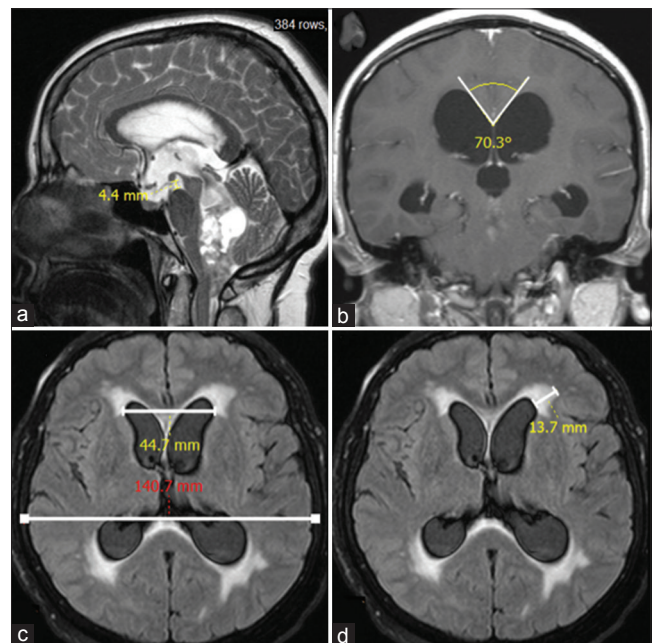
Types of linear measurement methods on magnetic resonance imaging images: (a) mammillopontine distance; (b) angle of corpus callosum; (c) Evans' index; (d) periventricular edema
